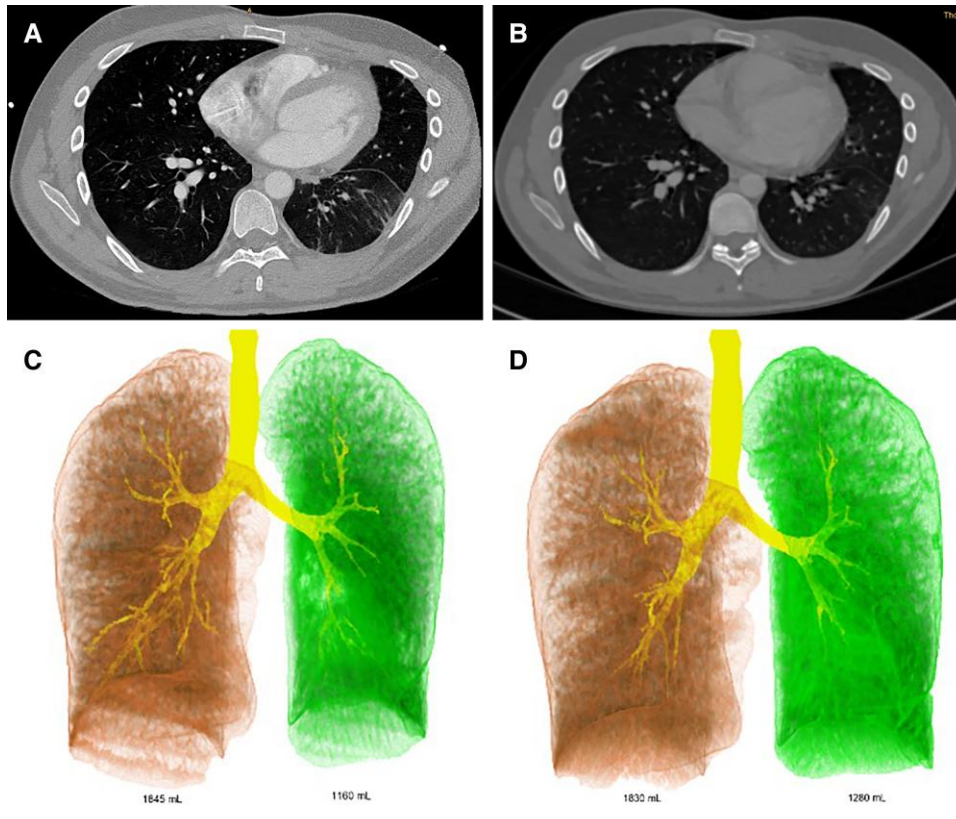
Lung space volumes pre and post-revascularization of both pulmonary veins. (A) Axial contrast enhanced computed tomography pre-intervention showing left-sided lung consolidation and chest asymmetry. (B) An improvement of lung volume and chest asymmetry after intervention. (C) Lung volumetry by chest computed tomography pre-intervention. (D) Lung volumetry by chest computed tomography post-intervention showed an increase in lung volume by 120 mL.
